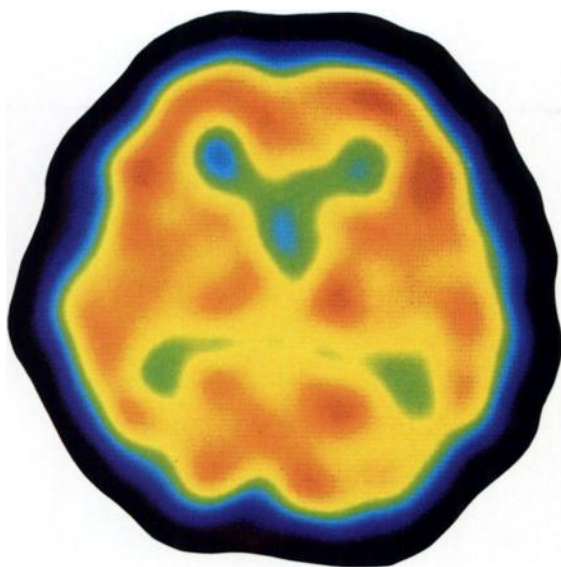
A normal SPECT study with iofetamine HCl I 123 shows relatively symmetrical uptake throughout the cerebral cortex.
